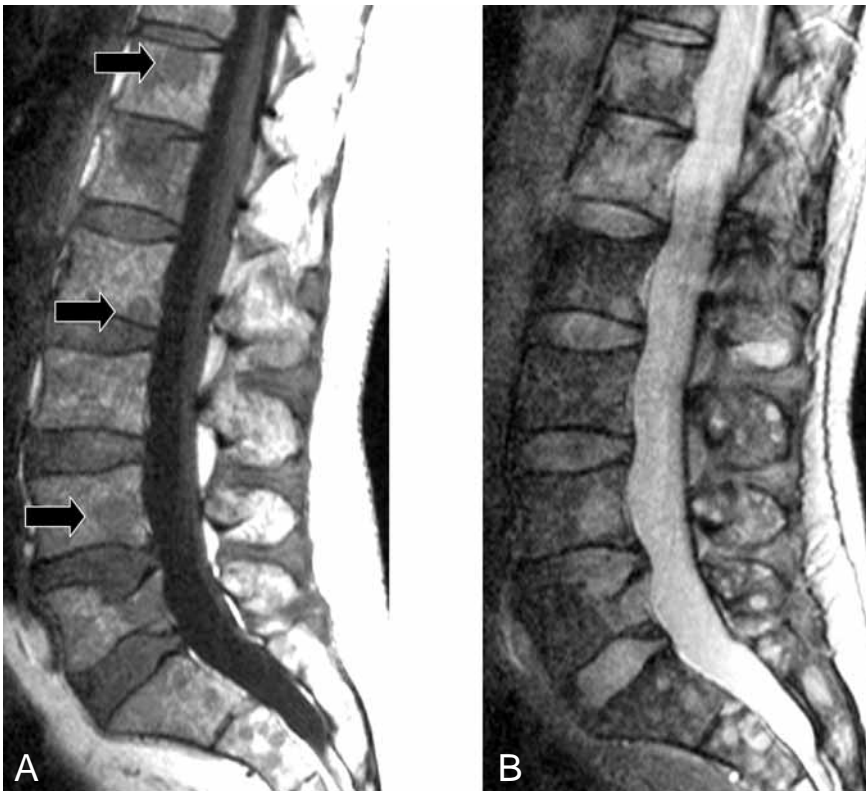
Lesion patterns. (a) Sagittal T1-weighted spin-echo and (b) T2-weighted gradient echo images of the lumbar spine of a patient with lumbar pain show focal marrow changes consisting of areas of low and high signal intensity on T1- and T2-weighted images respectively (arrows). Diffuse marrow changes are also visible on the T1-weighted image as disseminated spots of low signal intensity. MR findings lack specificity but the triad of focal lesion, diffuse infiltration and vertebral fracture suggests multiple myeloma (confirmed at iliac crest biopsy).
